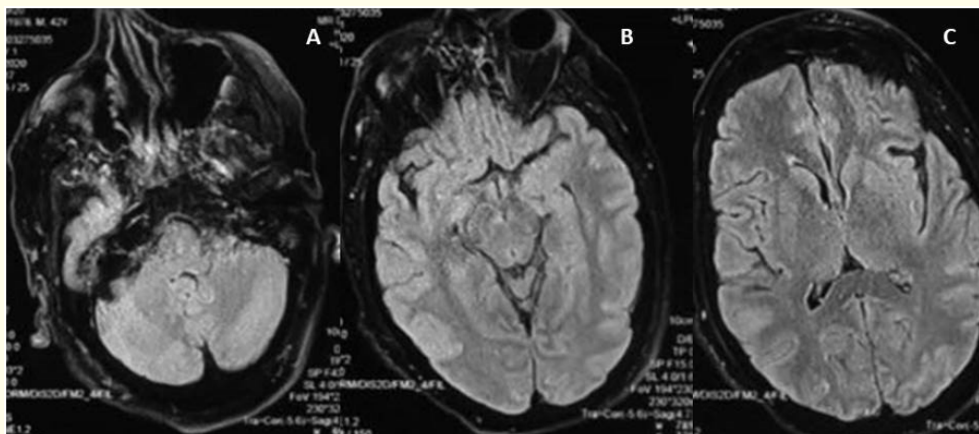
A,B and C showing Normal FLAIR MRI of brain during hospital admission.
